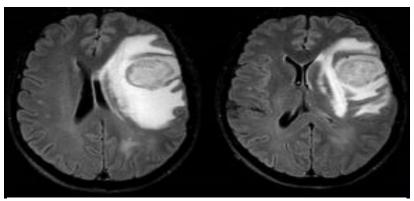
2. brain MRI axial cut (flair) appearance of a cerebral glioma.
